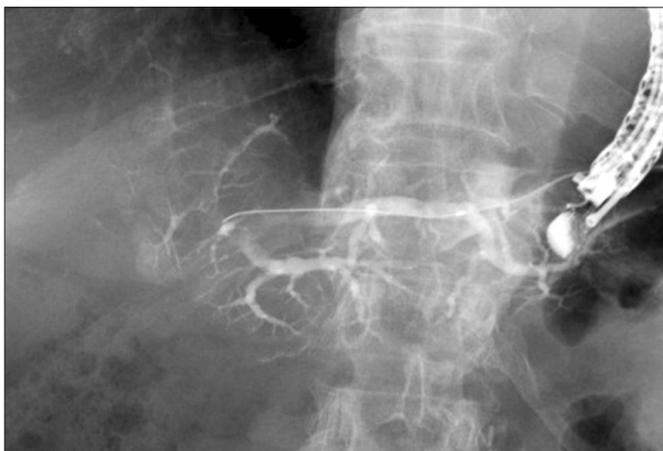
Endosonography-guided portography. It was obtained by miss-puncturing.
